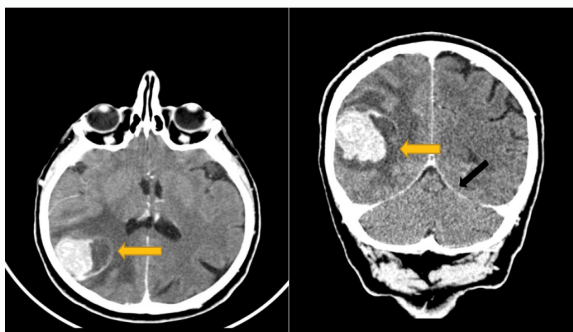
Two dimension pre-operative CT brain scan of a 53 year old male who presented with epileptic seizures and headache, yellow arrows showing the lesion black arrow points the tentorium cerebelli.
